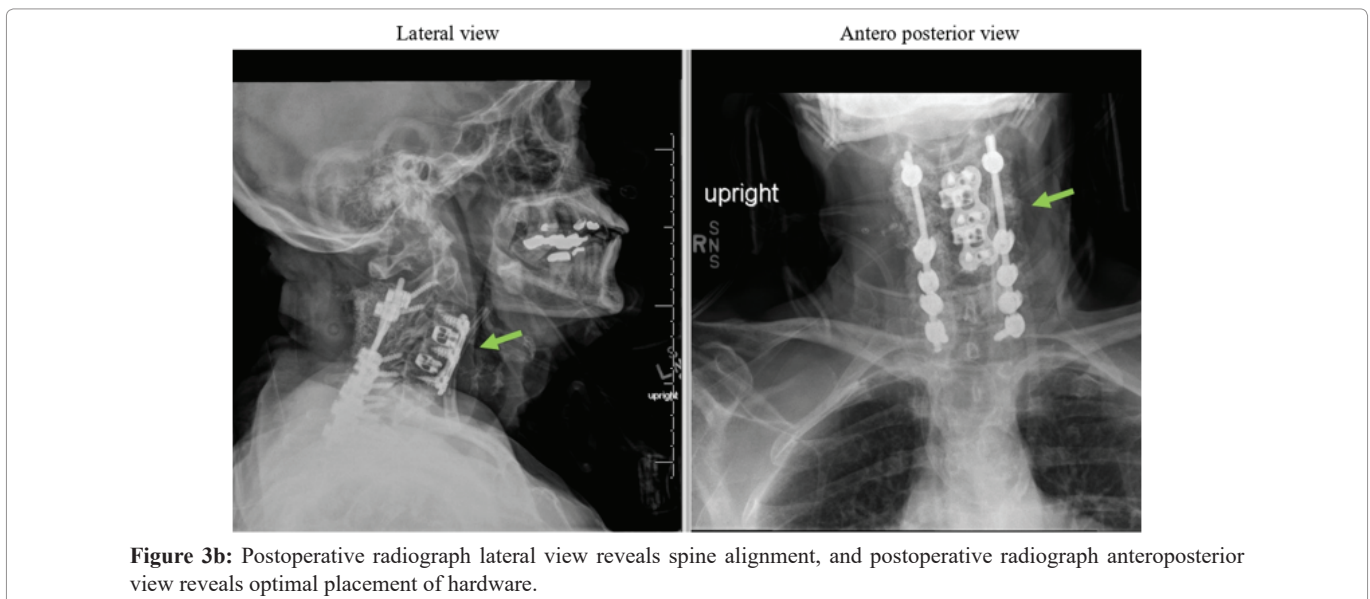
Postoperative radiograph lateral view reveals spine alignment, and postoperative radiograph anteroposterior view reveals optimal placement of hardware.
